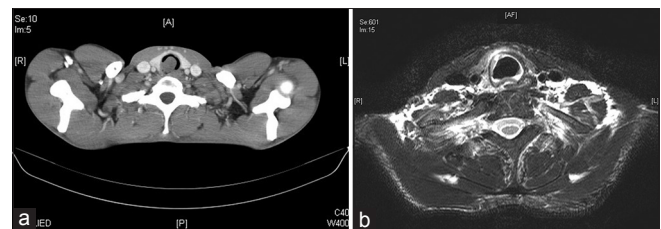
(a) Pre-operative computed tomography (b) Post-operative magnetic resonance imaging
